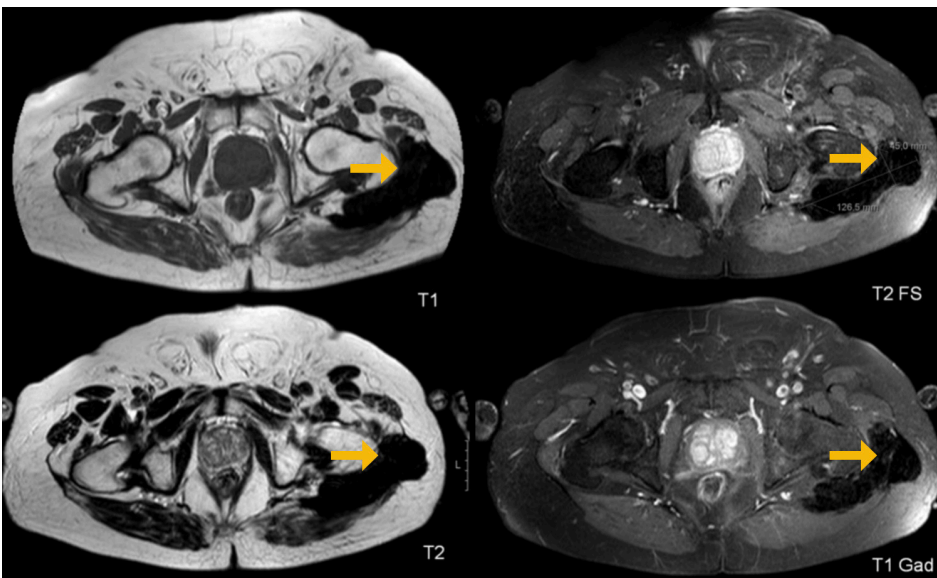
Deep fibromatosis (late stage) of the left gluteal region in a 34-year-old female. MR images showing an infiltrative mass centered in the left gluteus muscles (arrows) with low signal intensity in all pulse sequences. Following gadolinium administration it demonstrates lack of enhancement.
